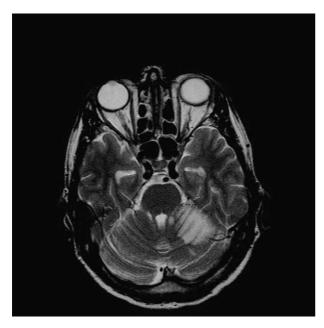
MRI scan showing a left cerebellar infarction.
